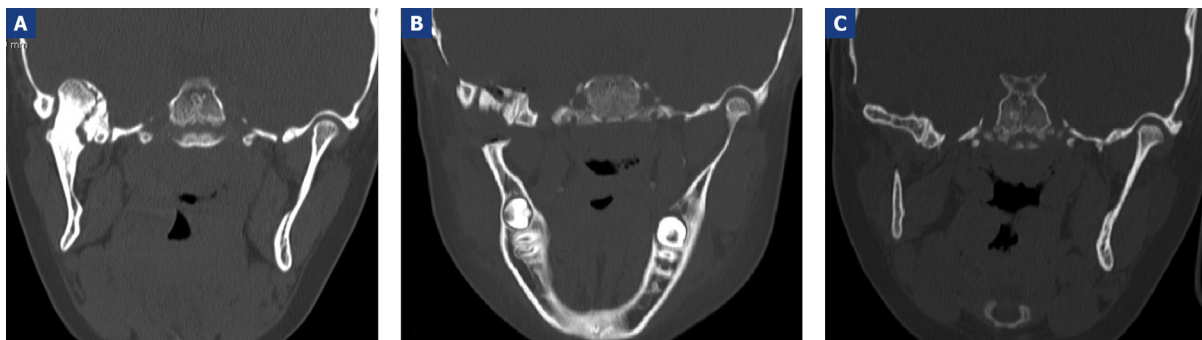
CT scan, frontal view; A: before surgery scan, showing an increased size and irregular anatomy of the right mandibular condyle compared to the left; B: after surgery CT scan, showing removal of the deformed condyle intruded in the middle cranial fossa with ankylosed mass remnant as a new roof of the right glenoid fossa; C: one year after surgery scan, showing a new roof of the glenoid fossa remodeled without any growth of the ankylosed mass remnant.
